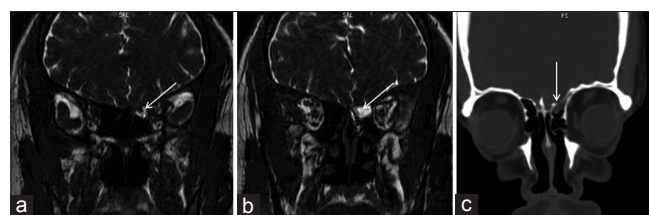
Coronal magnetic resonance imaging fast imaging employing steady-state acquisition images (a and b) showing pooling of cerebrospinal fluid (CSF) and herniated left frontal lobe (arrow) into the left ethmoidal air cells suggestive of meningoencephalocele and (c) coronal computerized tomography image shows bony defect (arrow) in the left cribriform plate with pooled CSF density fluid
